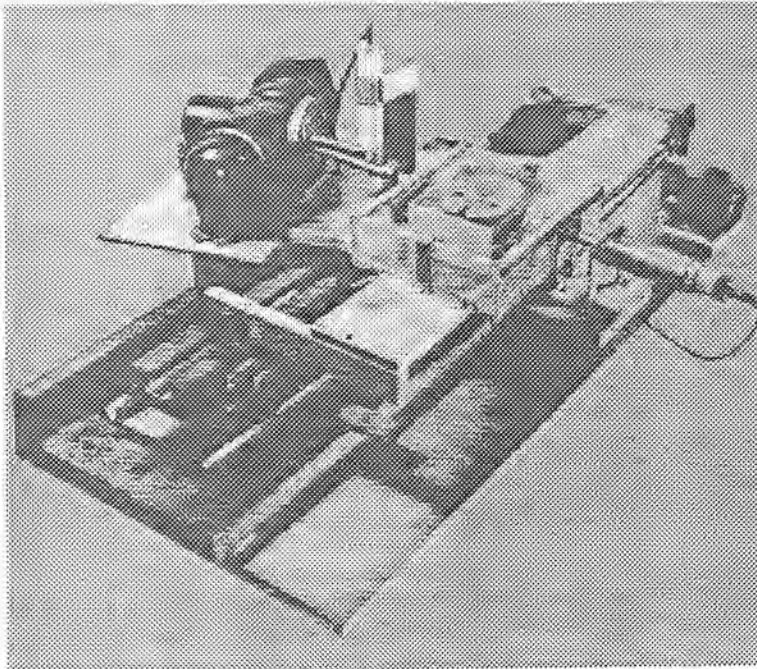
The original lathe bed scanner used in early CT experiments by Hounsfield of EMI (Webb 1990).
